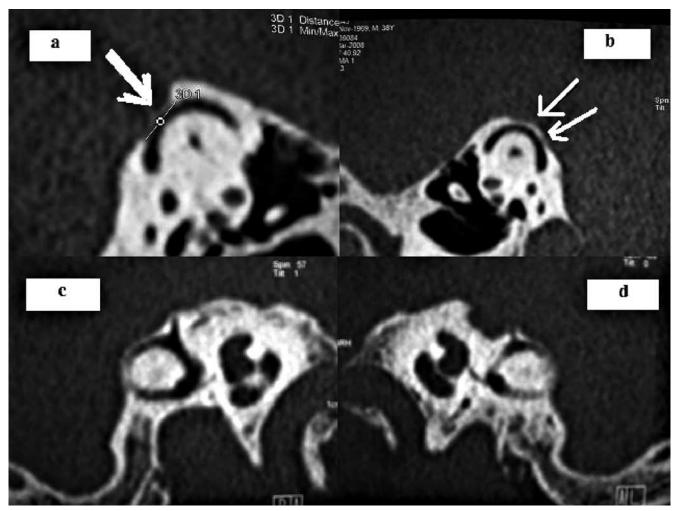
a-d. CT scan, sagittal projections showed bilateral dehiscence of posterior semicircular canal in right ear (3c) and left ear (3d), and unilateral right dehiscence of the superior semicircular canal (3a white arrow). White arrows in 3b instead show the bone covering the left superior semicircular canal.
